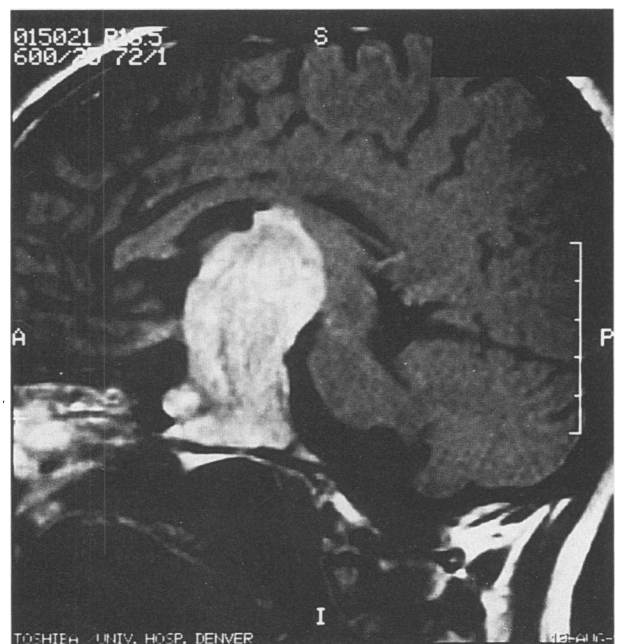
Temporolimbic tumor.* Patient 8 was amnesic for a year before this T1-weighted, enhanced sagittal magnetic resonance imaging scan disclosed a pituitary macroadenoma that upwardly displaced the fornical columns and thalami (TR = 600 msec, TE = 25 msec). Debulking yielded substantial improvement in her memory.
